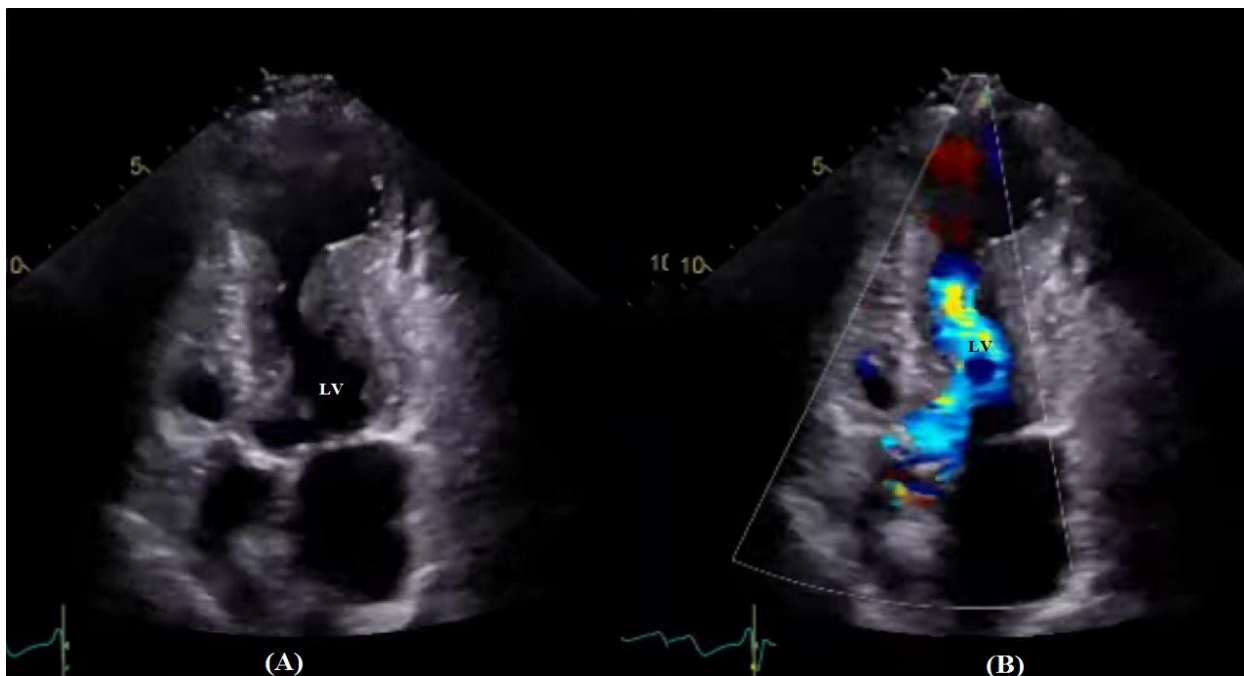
Left Ventricle wall thickening. (A): a 2D echo image of LV thickening. (B): interpretation of image (A) with a color Doppler.
